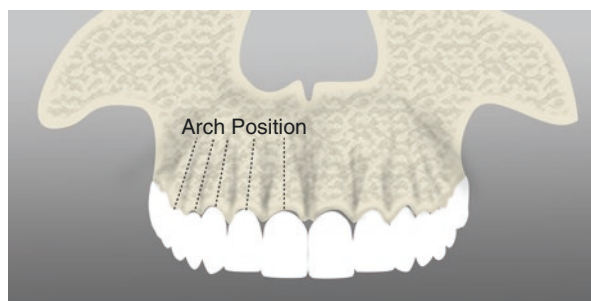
The fourth axis is the *arch position*. This is to take into consideration the angulation of the jaw as we move around the arch. In the maxilla, it forms a somewhat cone shape, with the apical end of the implant being tipped palatally, while in the mandible it is generally the opposite due to the lingual concavity. Cross-sectional CBCT slices will aid the clinician in determining the appropriate angulation for the given patient
